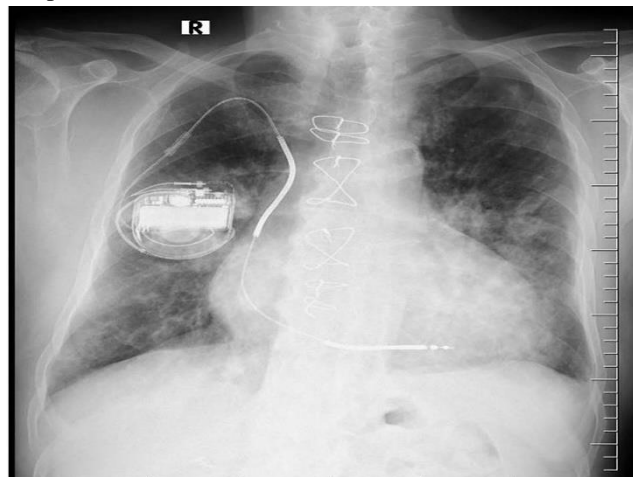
Chest x-ray showing the intracardiac device of the patient.
